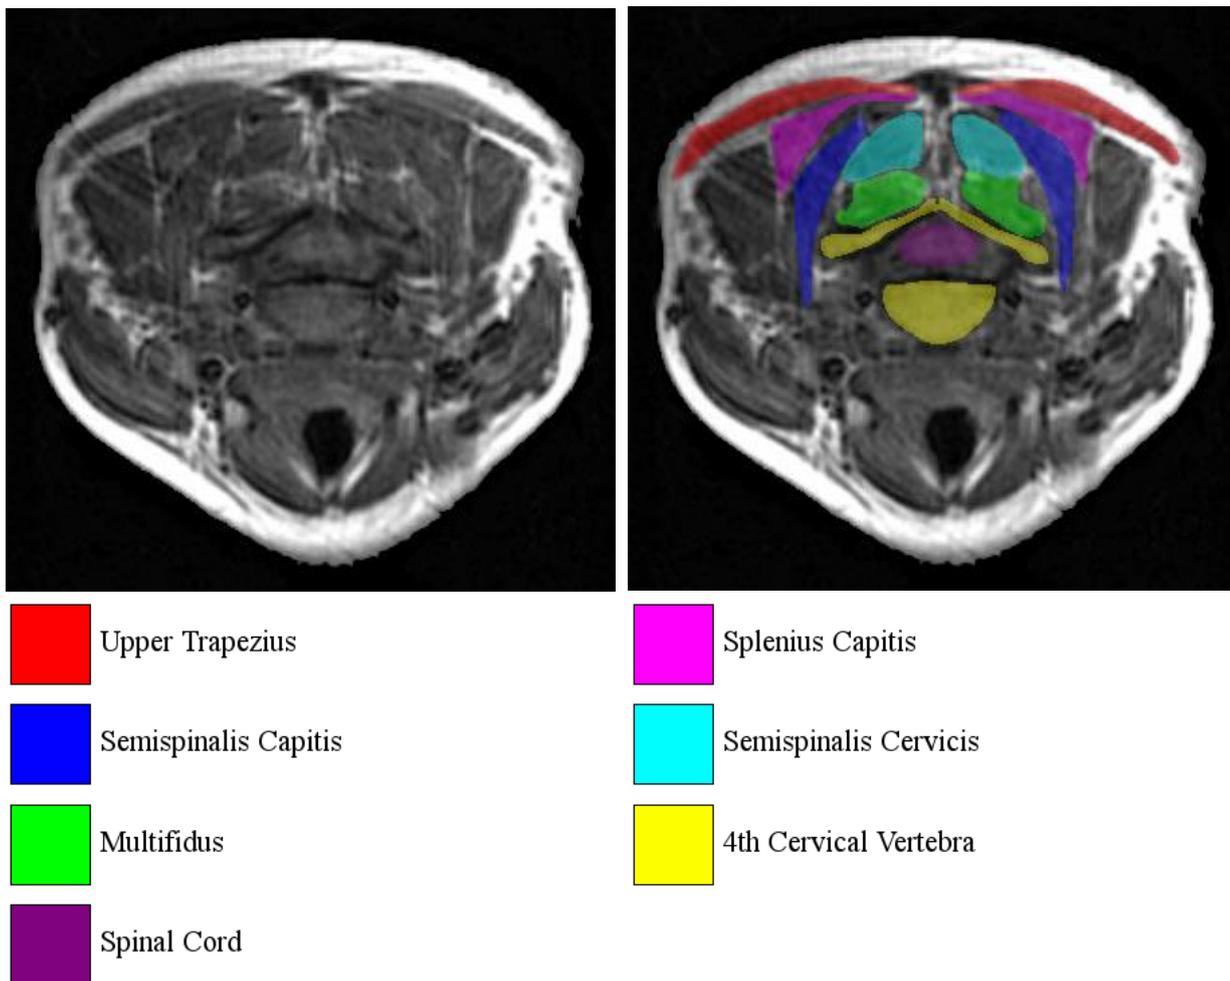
Posterior neck muscle anatomy. A transverse MRI cross-section of the human neck is shown on the left, while a colour-coded version of the same image is shown on the right. There are many identifiable muscles representing 5 symmetric layers of muscle (triceps, splenius, semispinalis capitis, semispinalis cervicis, and multifidus). Other muscles make up the rest of the posterior neck however, these muscle are not identifiable in these images due to their small size and/or vertical location in the neck.
